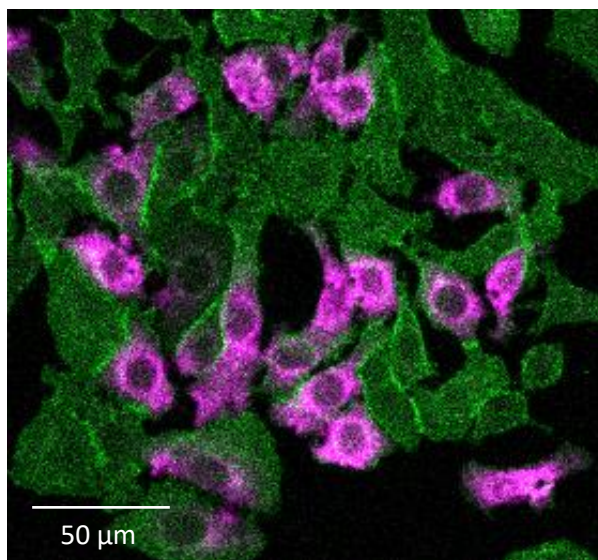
Representative image of Rose Bengal distribution in A549 cells after the cells were exposed to ultrasound in the presence of RB (no PI present in this sample; green colour represents Cell Mask Green, purple - RB). Images courtesy of Veerle Brans.
